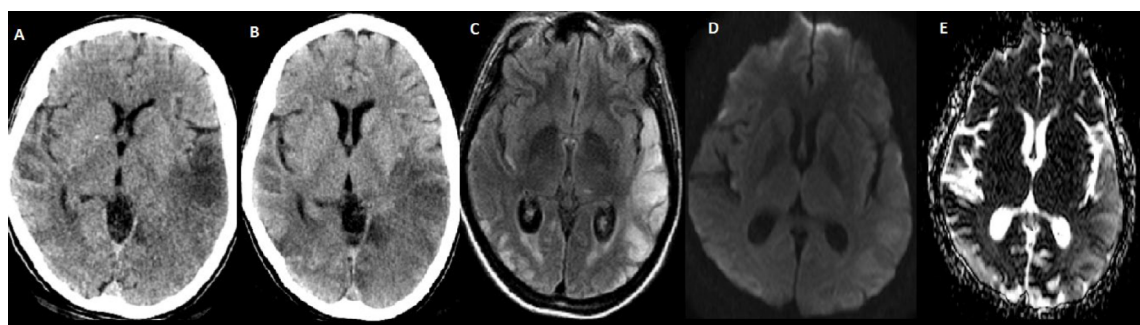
Brain computed tomography during hospital admission (A), 72 hours later (B), and fluid attenuated inversion recovery imaging (C) demonstrating bilateral lesions that do not respect arterial vascular territories. Diffusion-weighted imaging and apparent diffusion coefficient (D–E) demonstrating T2 shine through effect, representing vasogenic rather than cytotoxic edema.
